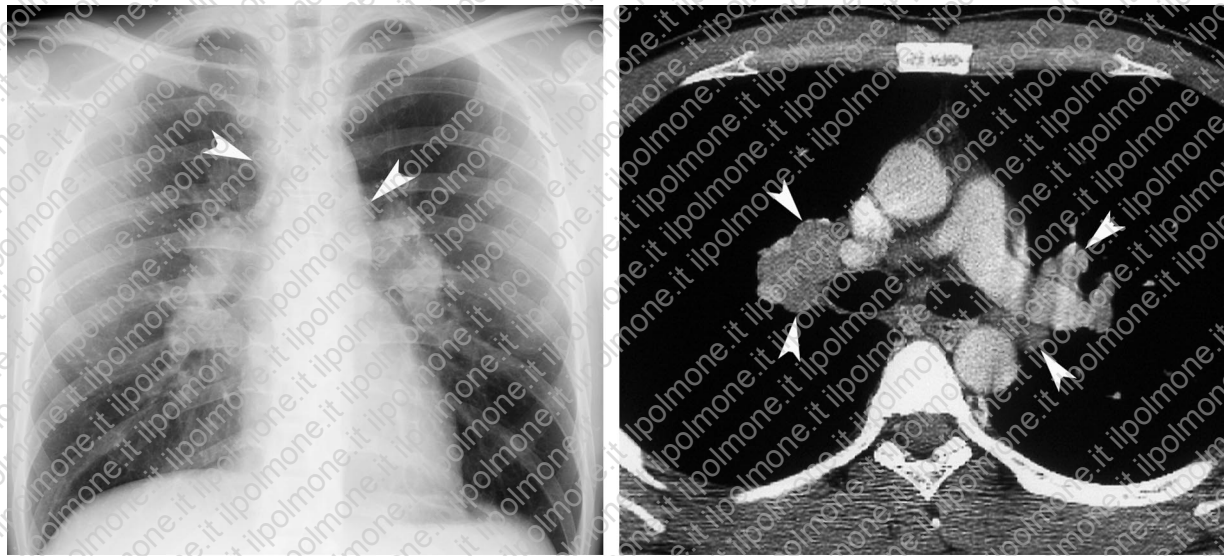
Hilar adenopathy in a 27-year-old man with Heerfordt syndrome. (a) Chest radiograph demonstrates typical bilateral hilar adenopathy. Adenopathy in the right paratracheal and left aortic-pulmonary window nodes (arrowheads) is also identified. (b) Contrast material-enhanced computed tomographic (CT) scan clearly depicts the bilateral hilar adenopathy (arrowheads).
